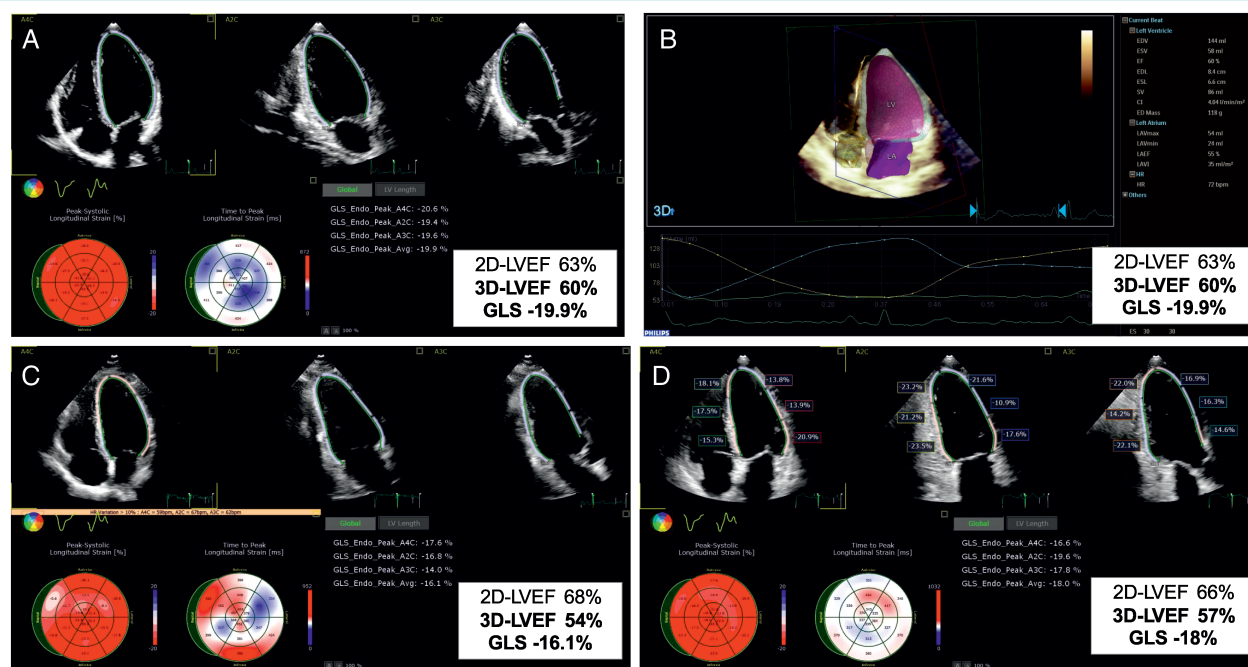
The case of a 66-year-old female with invasive breast ductal carcinoma (ER+ HER2+) treated by the combination of doxorubicin, cyclophosphamide, paclitaxel, radiotherapy (35 Gy + 10) and trastuzumab. (A) Baseline apical two-dimensional (2D) echocardiographic four-, two- and three-chamber views, showing normal left ventricular ejection fraction (LVEF), with speckle tracking-derived bull's eye and normal global longitudinal strain (GLS). (B) Baseline three-dimensional (3D) volumetric analysis of the left ventricle and left atrium; measurements are normal. (C) At 3-month follow-up, 2D LVEF remains normal, while 3D LVEF drops by 10% and GLS by 19%. This entailed the initiation of anti-remodelling treatment with no interruption of oncologic drugs. (D) At 6-month follow-up, while continuing cancer and cardiac medications, the 3D LVEF reversed by 5%, and GLS recovered by 10%. LA, left atrium; LV, left ventricle.
